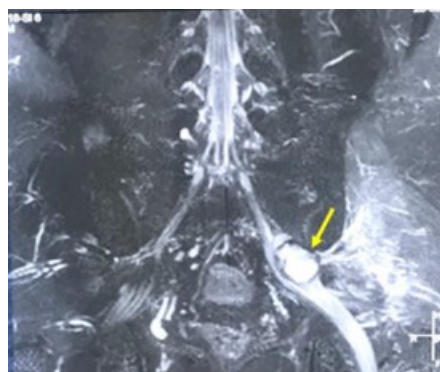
MRI of lumbosacral plexus showing post-stab left lumbosacral trunk injury with neuroma. Arrow indicates injury site. Source: Figure by authors.
